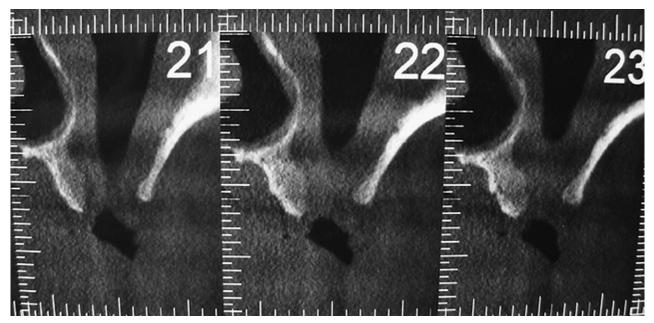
Sagittal computed tomographic section shows an oroantral fistula 10 mm in diameter. Er et al. Bony Press-Fit Treatment of Oroantral Fistulas. J Oral Maxillofac Surg 2013.
